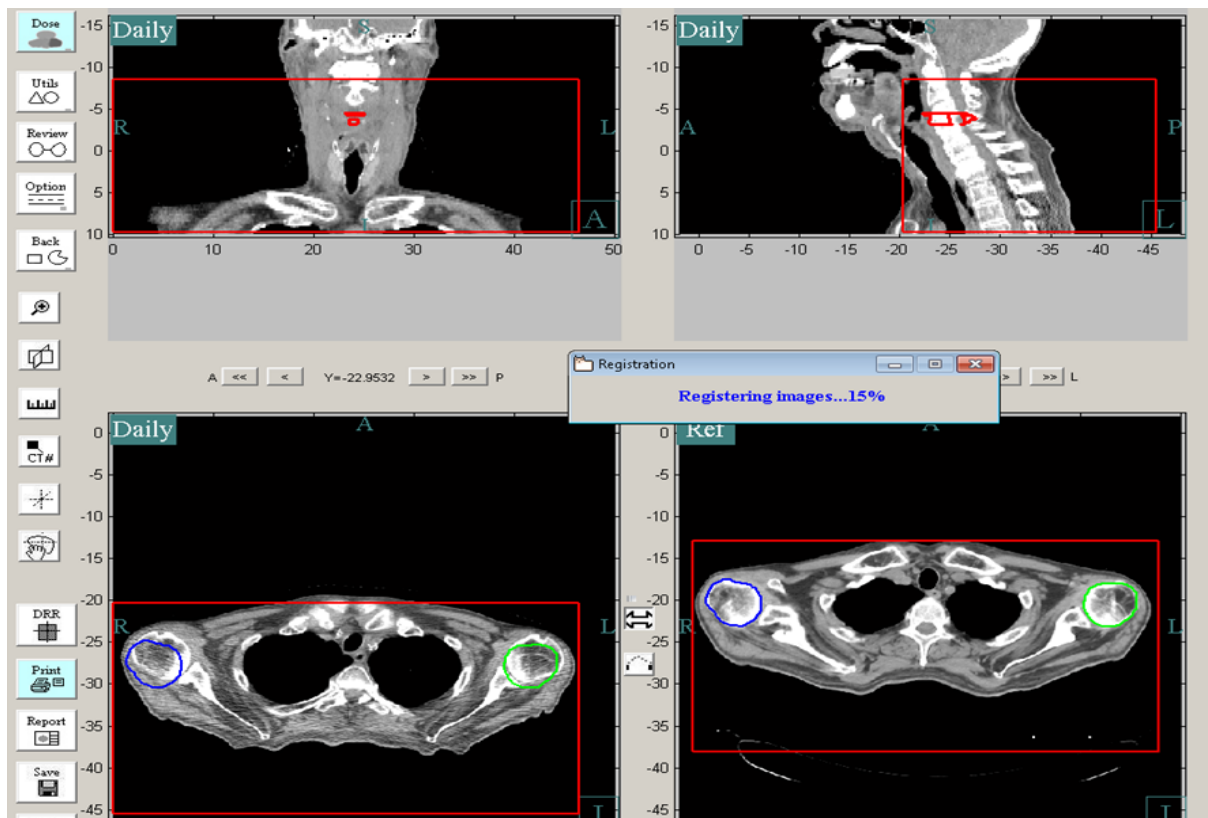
CAT registering images: The structures drawn on the Reference scan on the bottom right are being aligned on the daily CT, bottom left.
